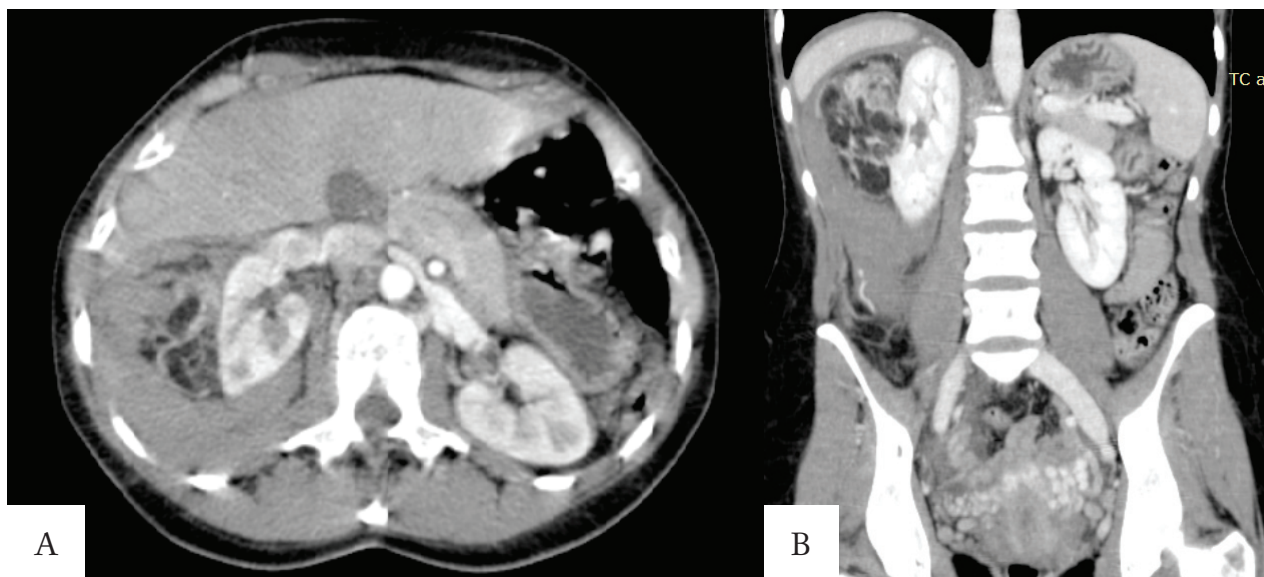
Contrast-enhanced abdominal CT scan in arterial phase with (A) axial and (B) coronal views which show a 6,3x5x8 cm mass that compressed laterally the right kidney characterized by hypervascularized and adipose areas with perirenal hematoma; free fluid in the lateroconal fascia and pelvic region is associated
